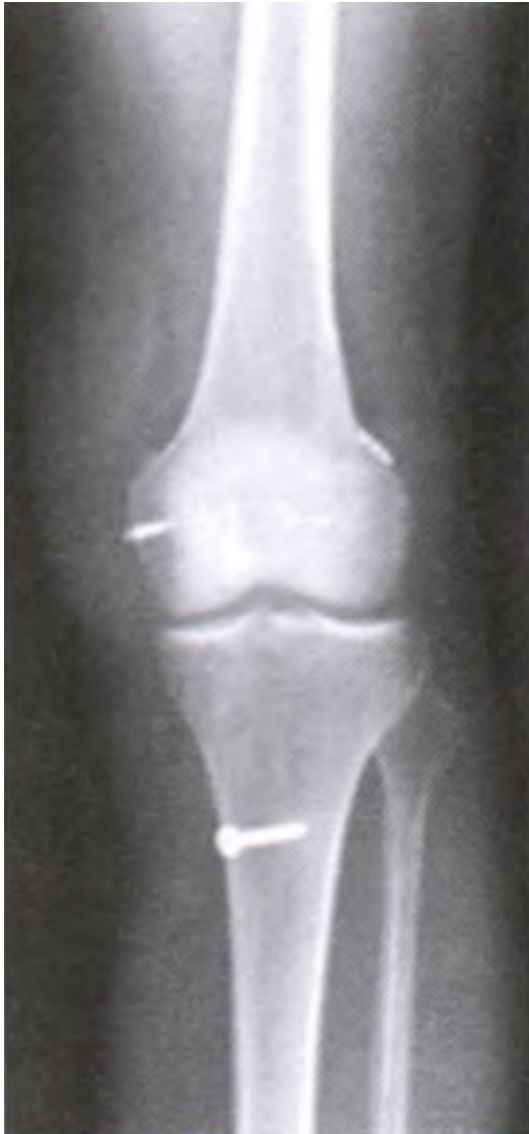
X-ray film showed that medial collateral ligament and anterior cruciate ligament were firmly fixed 1 d after operation.
